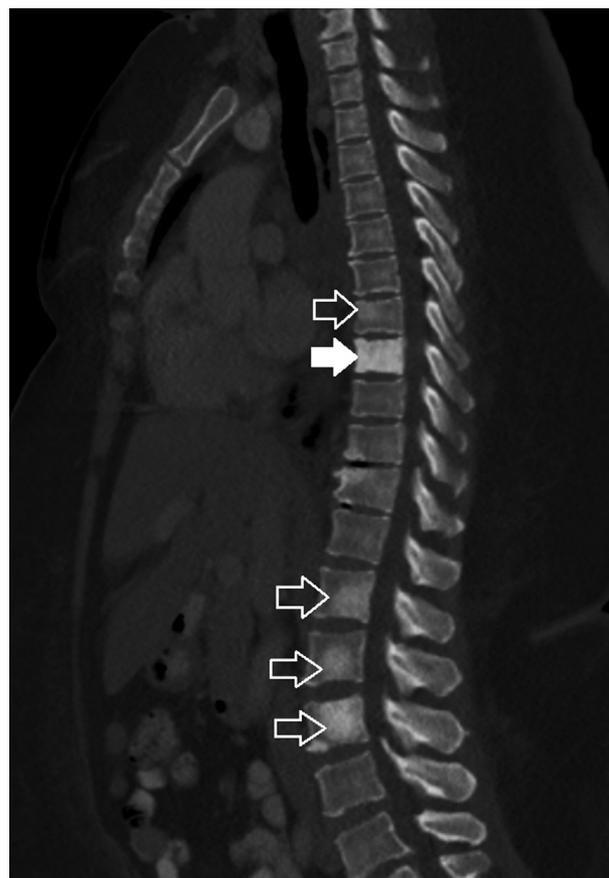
CT of the chest, abdomen, and pelvis (coronal view, bone window) showing complete sclerosis of the T8 vertebral body (solid arrow) and other sclerotic lesions throughout the thoracic and lumbar spine (hollow arrows), without loss of vertebral body height or other abnormality to suggest fracture.
